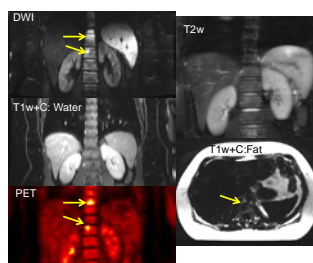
Spine metastases most conspicuous on DWI and relatively inconspicuous on T2w and T1w+C water images.
